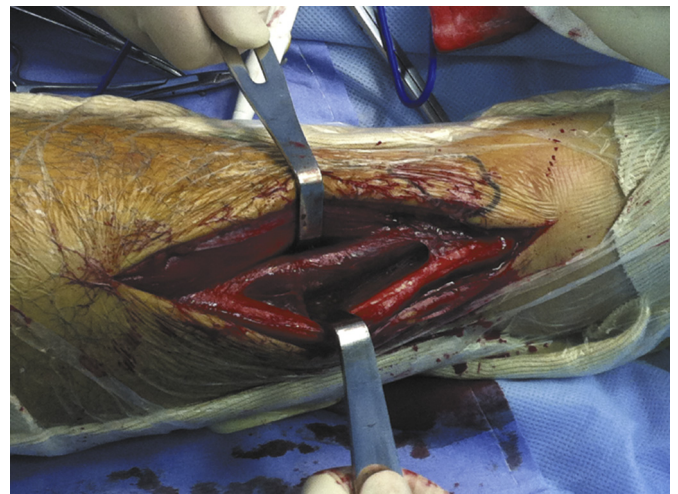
Operation of fasciotomy shows section of EHL and EDL necrosis with ashen gray in color corresponding with MRI performance.
